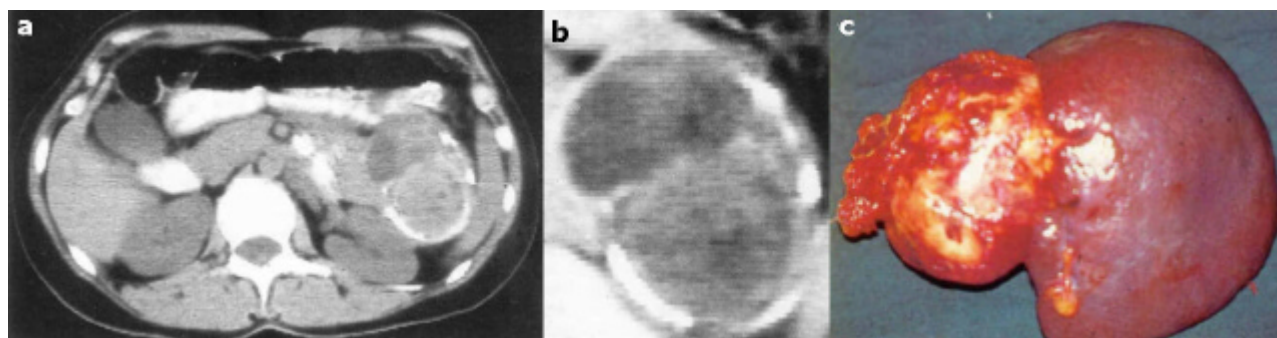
Case 1. A CT scan showing a round, encapsulated 8x5 cm mass of the pancreatic tail with non-homogeneous density (a.), a fibrotic capsule and multiple foci of central and marginal calcifications (b.). The tumor mass was completely removed with a distal pancreatectomy and splenectomy (c.).
